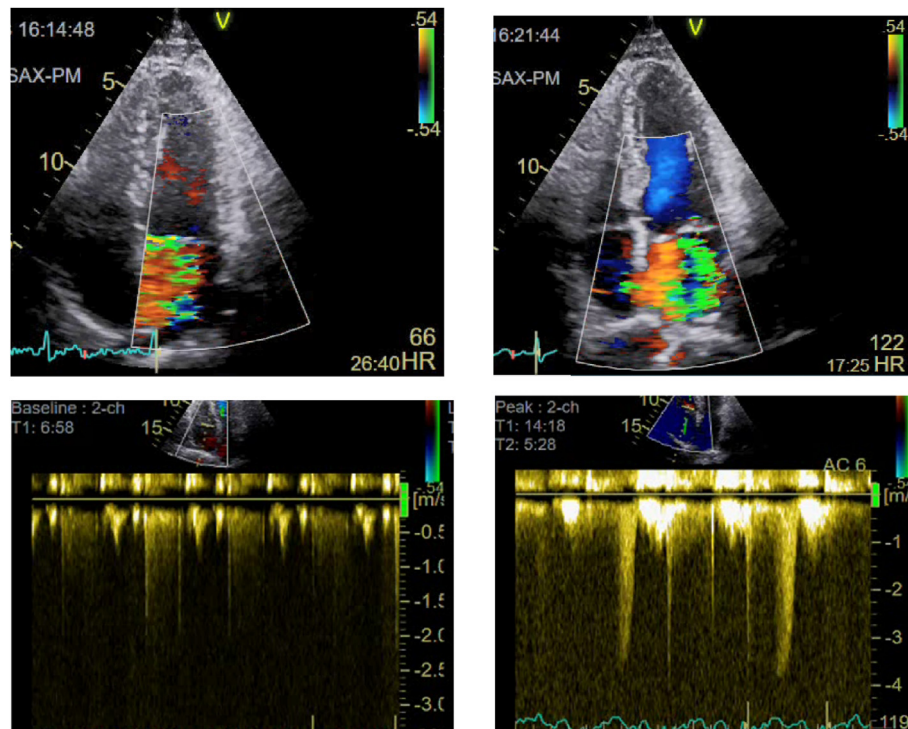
Exercise stress echocardiography in an asymptomatic patient with moderate to severe MR and normal PASP at baseline. Semiquantitative assessment of MR regurgitation, using MR jet area, and detection of exercise-induced pulmonary hypertension at early peak accompanied by severe dyspnea.
